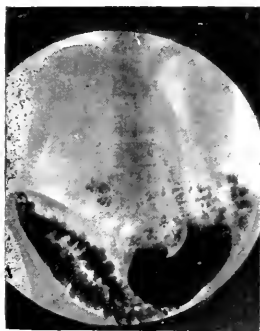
Immediate and twelve hour roentgenogram showing excessive descent of cecum in young woman of asthenic type. (Plate taken in erect position.)
